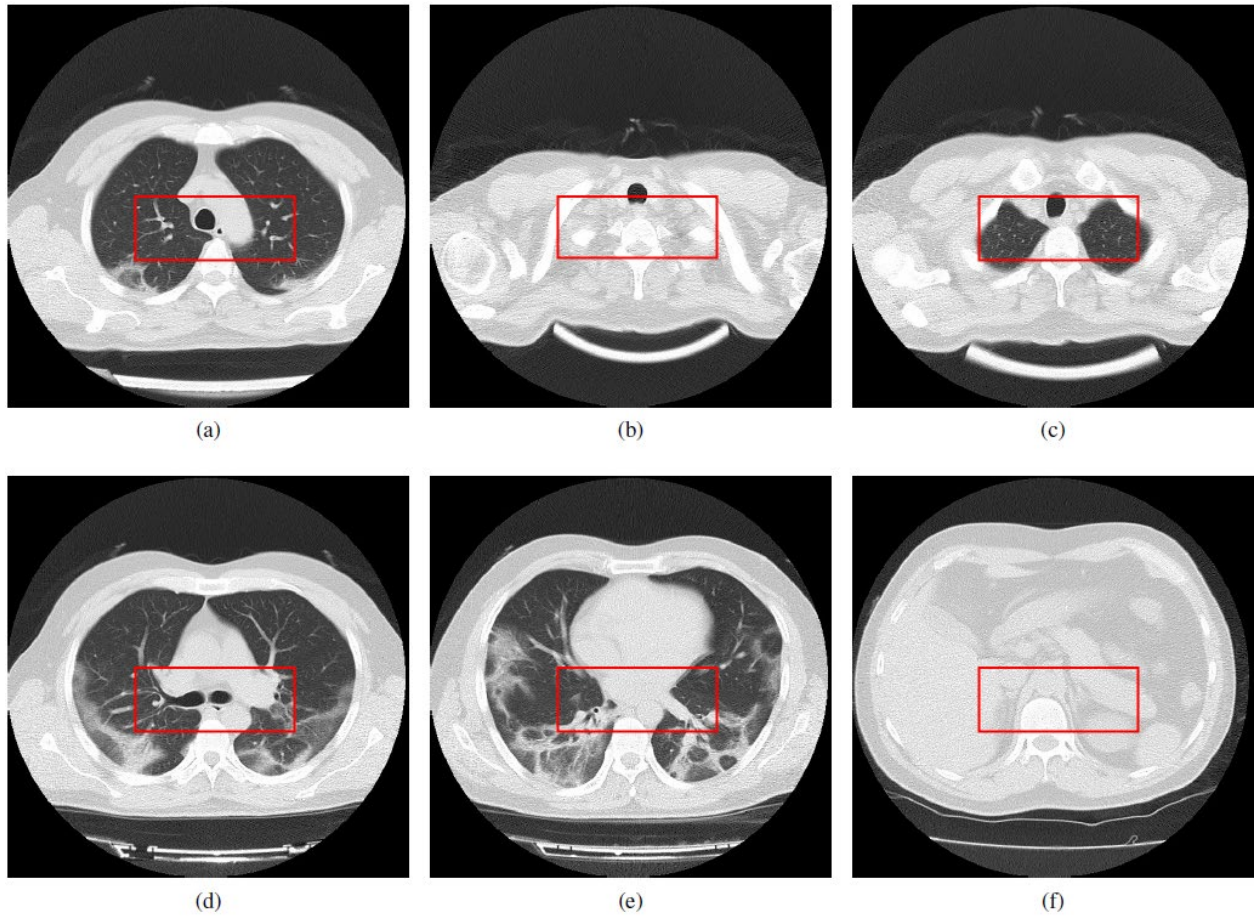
Extracting a specific region from the CT scan lung images
